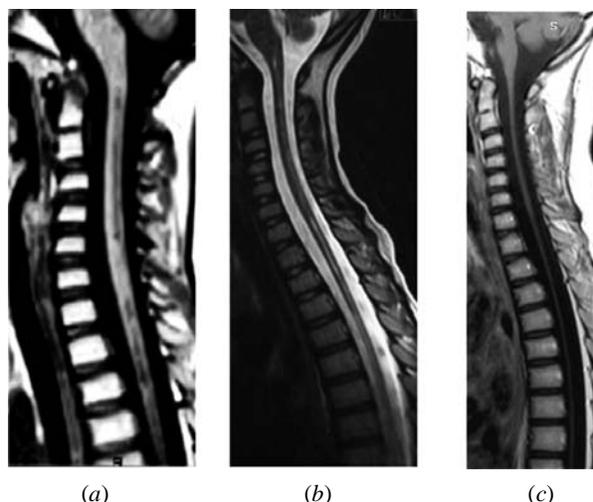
Progression of spinal cord atrophy shown on MRI (a) at the second relapse; (b) at the third relapse; and (c) after third relapse.
